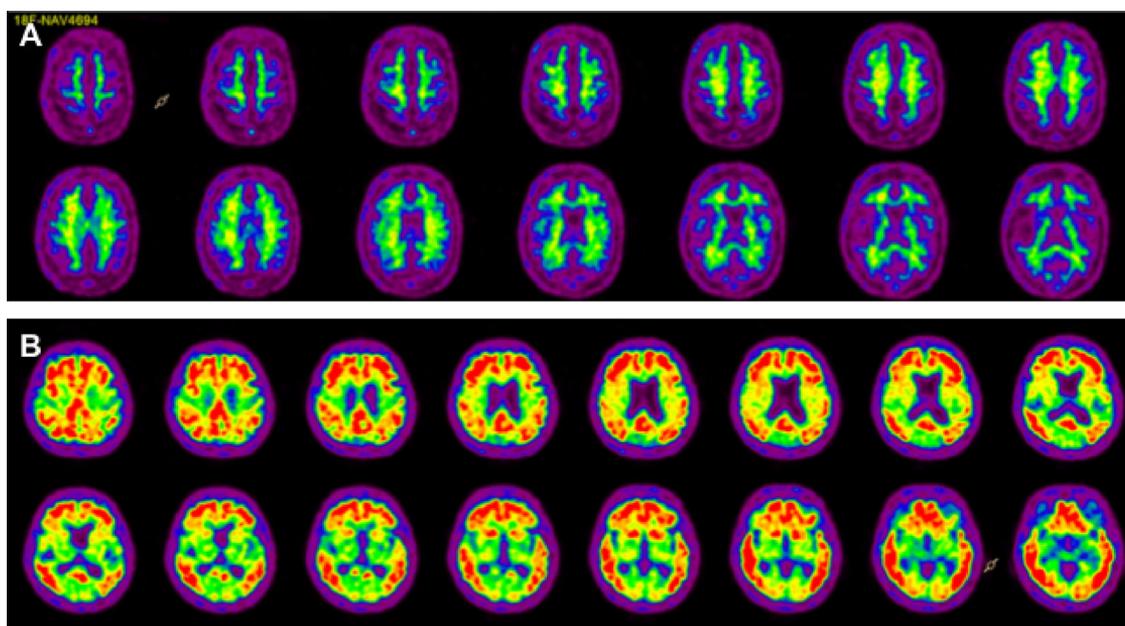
Axial imaging of β -amyloid with ^{18}F -NAV4694 PET/CT. (A) Negative study with normal amyloid distribution in the white matter. (B) Positive study, with significant amyloid distribution in the grey matter in both lobes, most marked in the frontal, precuneus, posterior cingulate, lateral parietal, lateral temporal cortex and striatum.
